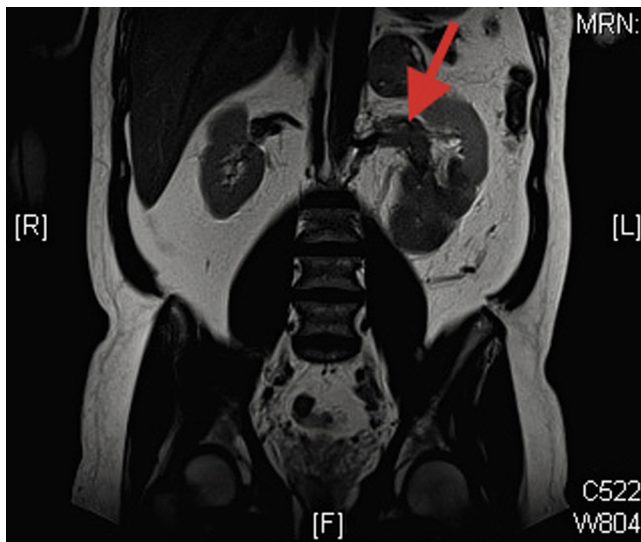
Abdominal MRI showing a left renal mass, (arrow) renal vein thrombosis.
